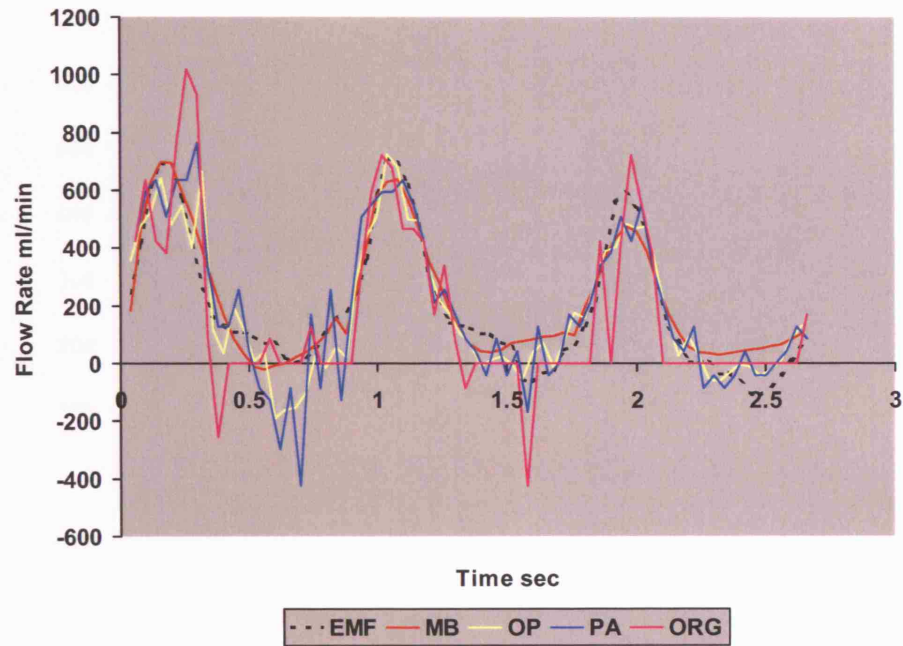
Stationary silicone tubing experiments: An example of x-ray calculated and EMF waveforms for the 6 mm diameter vessel. The mean EMF flow rate was 198 ml/min.
